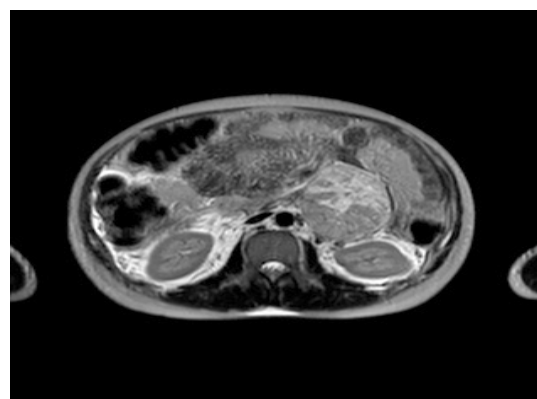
MRI Abdomen and pelvis.
